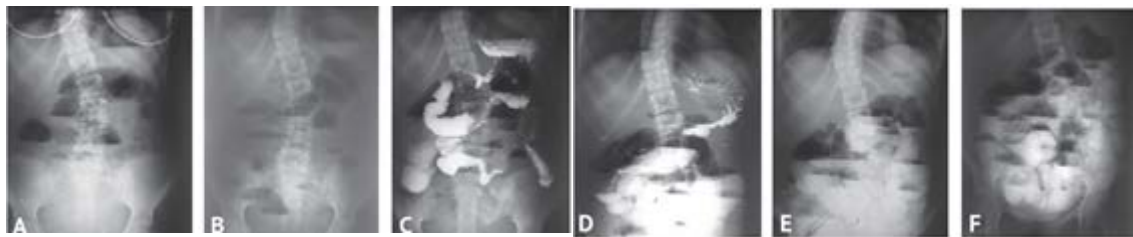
A series of X-rays of the abdominal organs with oral contrast (barium sulfate): A — plain X-ray upon admission; B — plain X-ray after bowel stimulation; C — plain X-ray one hour after BaSO₄ intake; D — plain X-ray image 3 hours after BaSO₄ intake; E — plain X-ray 6 hours after BaSO₄ intake; F — plain X-ray 12 hours after taking BaSO₄
